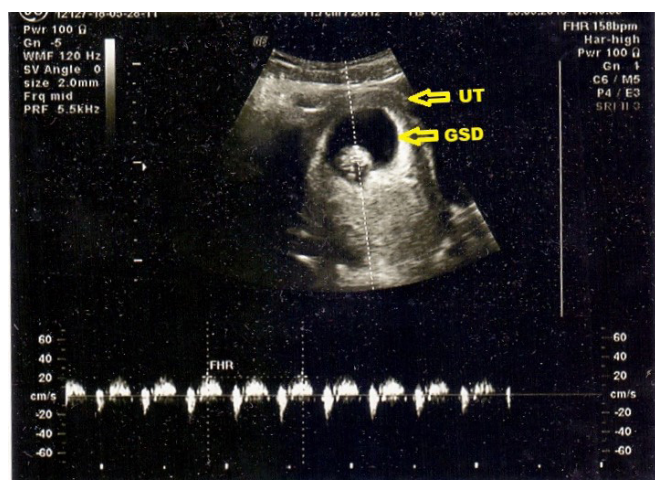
Normal ultrasound of a gravid uterus. Ultrasound image of a live foetal pole with cardiac activity. The Pouch of Douglas is free of fluid.
